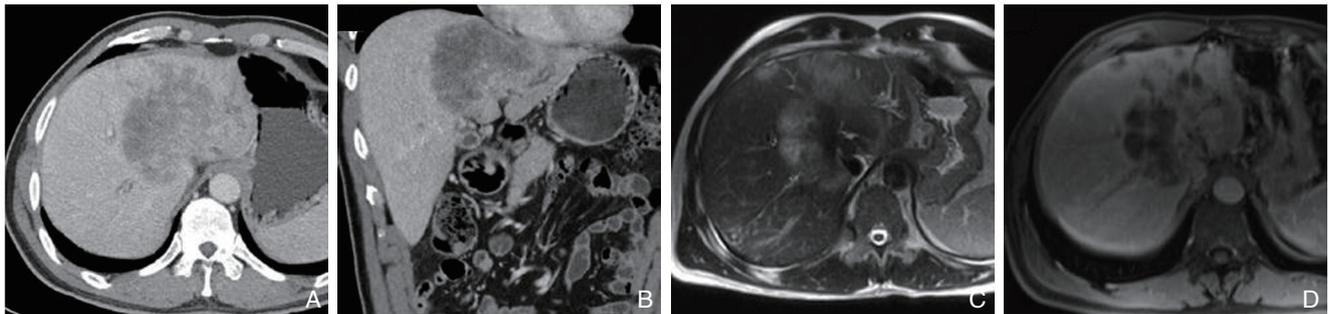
A, B 为肝静脉期 CT 示肝脏巨大不均质肿块; C 为 T₂ 像及对比门静脉期增强核磁; D 示由于巨大的肿块而引起胆管扩张
